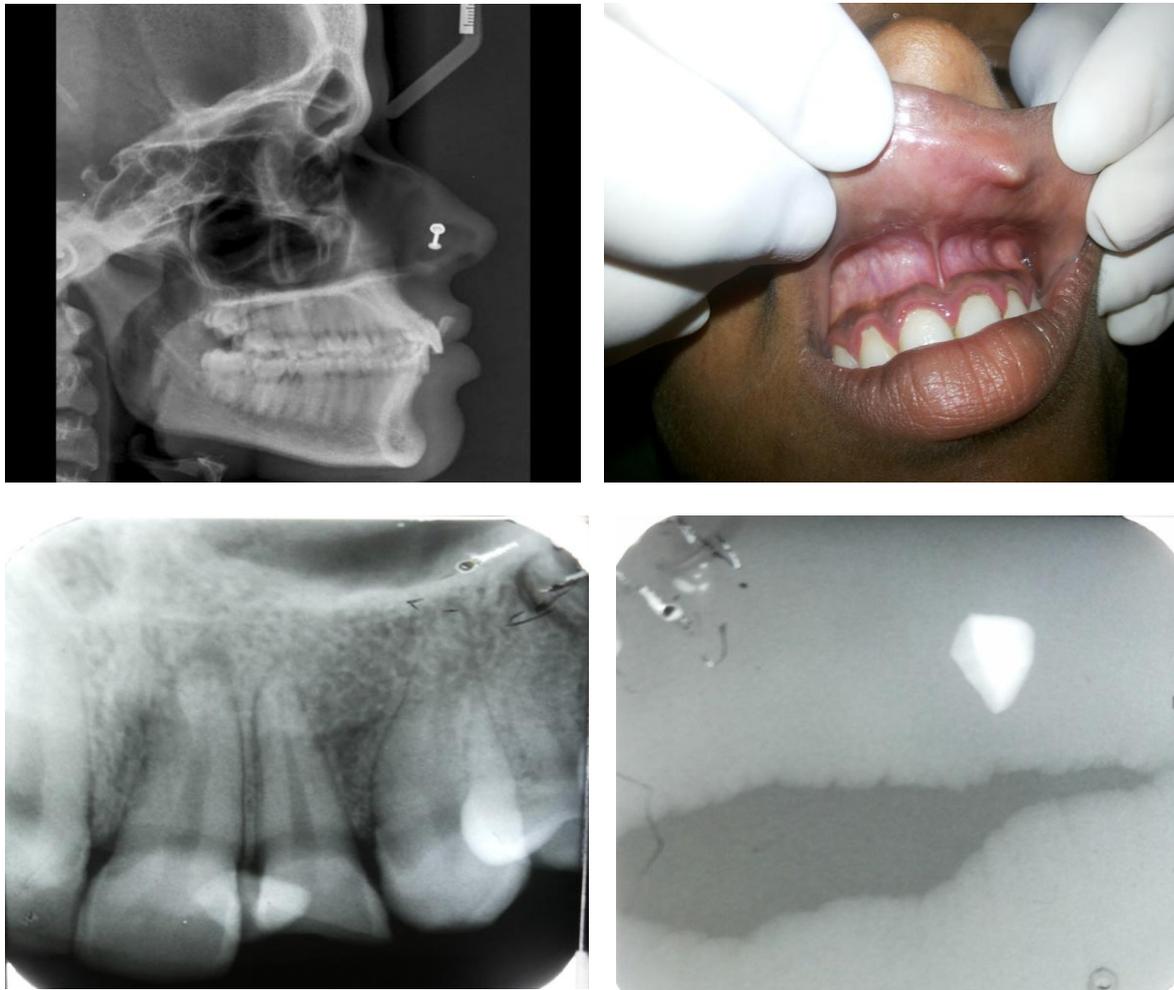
to 4: image of the upper lip radiograph showing trapezoidal radio-opaque structure embedded in the soft tissue shadow
